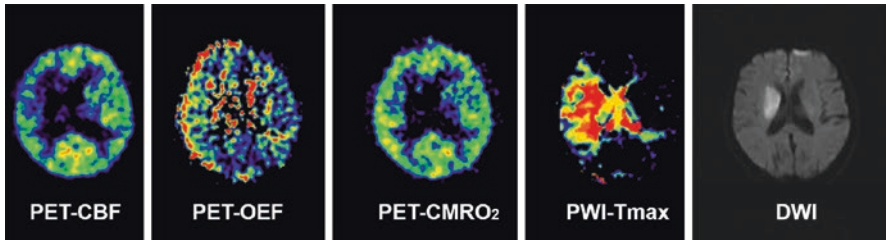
Coregistered images of multitracer ^{15}O -positron emission tomography (PET), magnetic resonance perfusion-weighted imaging (PWI) time to maximum (Tmax) and diffusion-weighted imaging (DWI) in a patient with acute ischemic stroke. The images show penumbral tissue on PET with reduced cerebral blood flow (CBF), elevated oxygen extraction fraction (OEF), and normal cerebral metabolic rate of oxygen (CMRO_2)
